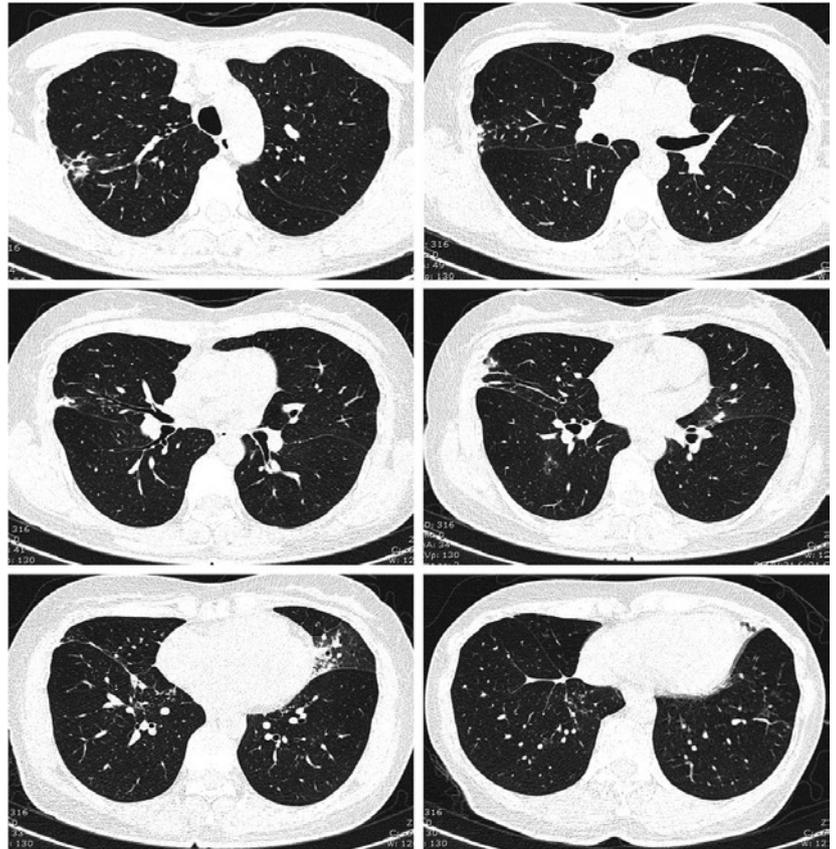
CT scan of the thorax 2 months after initial presentation.
